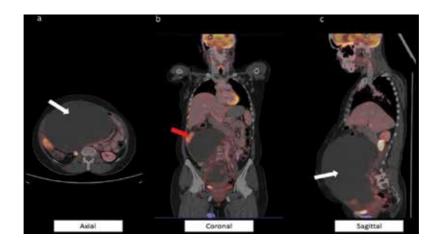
PET/CT scan demonstrating an advanced ovarian cancer. White arrows show a large adnexal tumour with heterogeneous FDG uptake. Red arrow shows bowel involvement.
